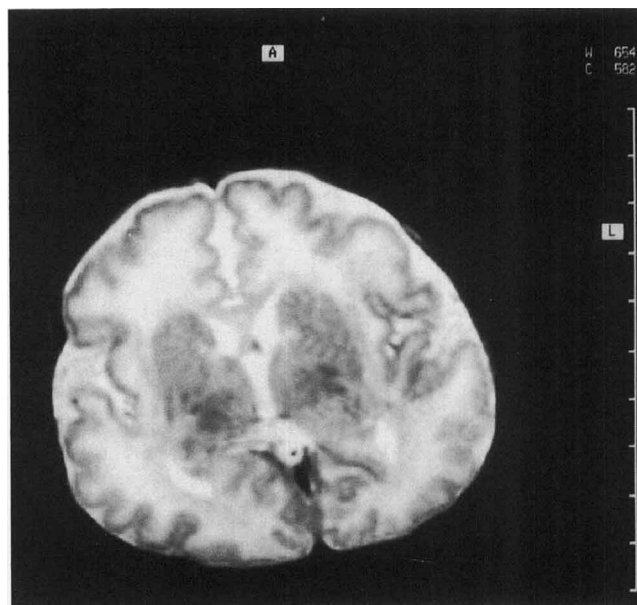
MRI axial T<sub>2</sub>-weighted image shows bilateral incomplete opercularization and diffuse abnormal signal in the white matter.
